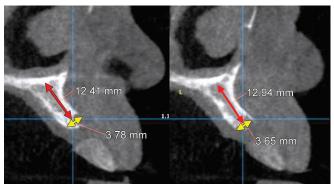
Presurgical bony analysis (CBCT) of the maxillary right central incisor region showing small course to condensed randomly oriented trabeculae (left) and intact mildly thickened cortices (right). Such patterns are typically suggestive of moderate or patchy low D3-type bone
